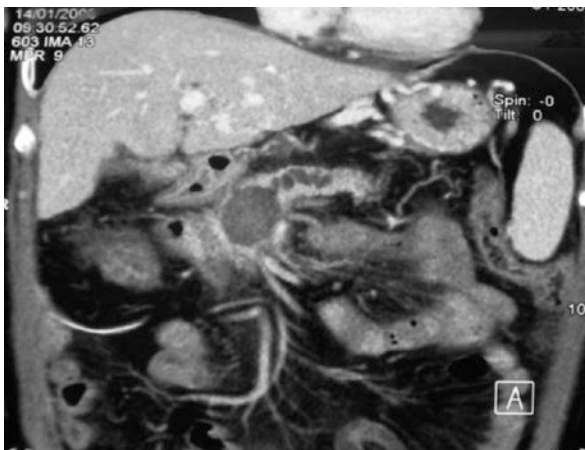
CT 1 month after RFA: hypodense area in the head of the pancreas
